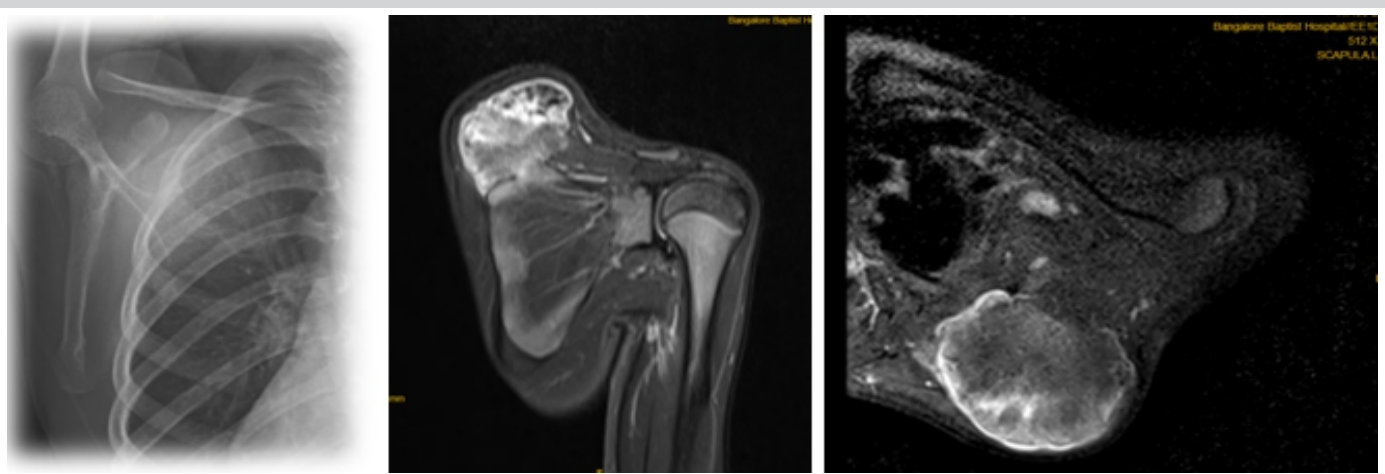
Preoperative radiograph showing an exophytic lesion with cortical continuity.
